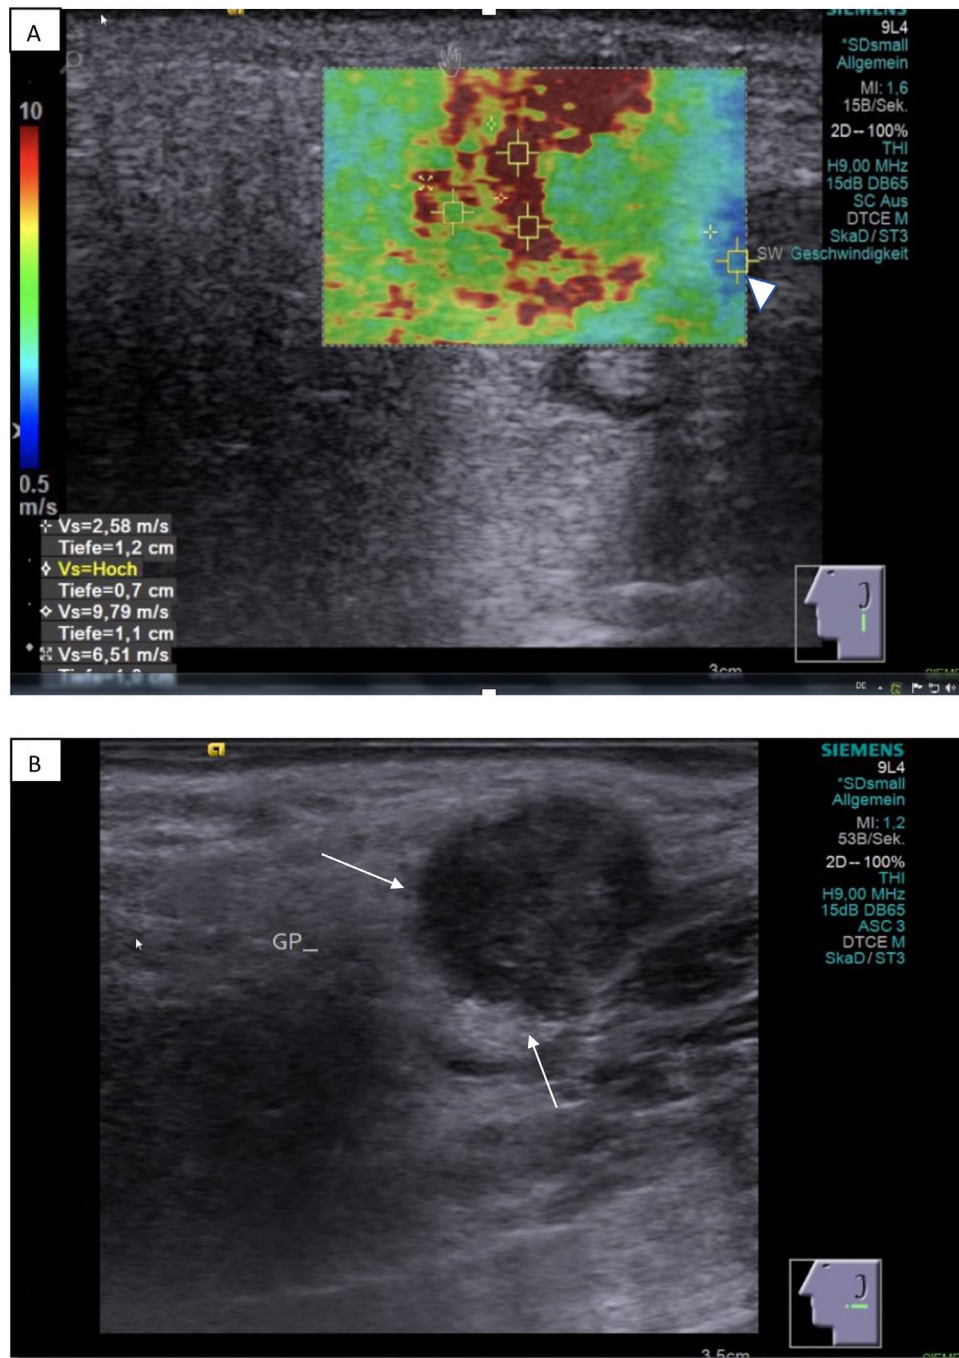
Representative B-mode ultrasound and Virtual Touch imaging quantification (VTIQ) of a malignant tumor. (a) VTIQ image of a squamous cell carcinoma in the left parotid gland. VTIQ measurements were obtained within the lesion in areas of slowest shear waves (color-coded in *green* in the image) and fastest shear waves (color-coded in *red*), as well as peripherally to the lesion (*arrowhead*). If shear wave velocities exceeded 10.0 m/s (denoted as V_s = "hoch" or high velocity on the equipment), the shear wave velocity was recorded as 10.0 m/s, as VTIQ only allows measurements of shear waves in the range 0.5 to 10.0 m/s. (b) Corresponding heterogeneous echogenicity on B-mode ultrasound with ill-defined margins (*arrows*).
